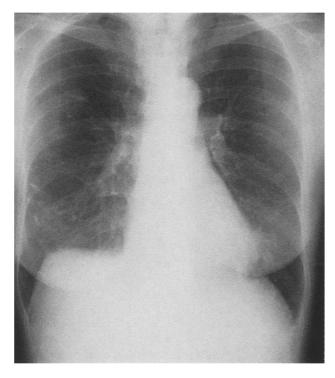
Chest X-ray taken in September 1994. No obvious lesions can be seen
